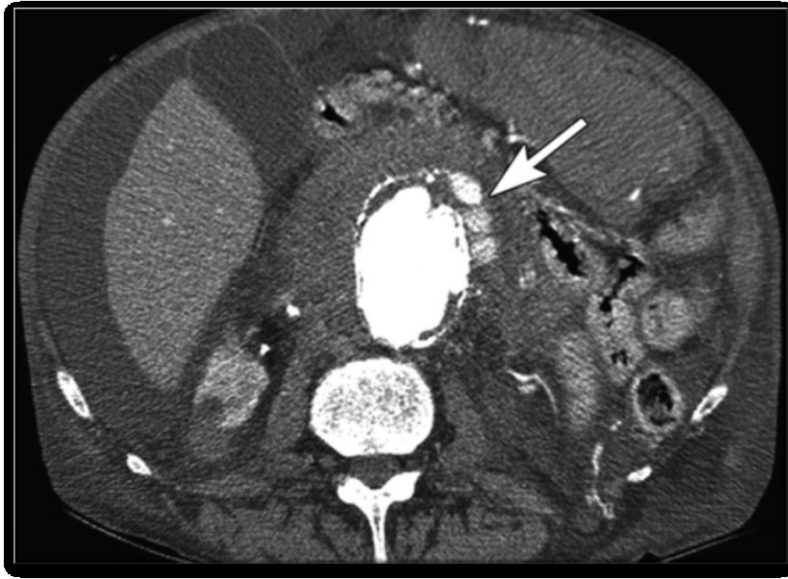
Contrast-enhanced axial CT displaying contrast extravasation (arrow) in a ruptured AAA patient. Adapted from Rakita et al. (2) Authorized reproduction.
